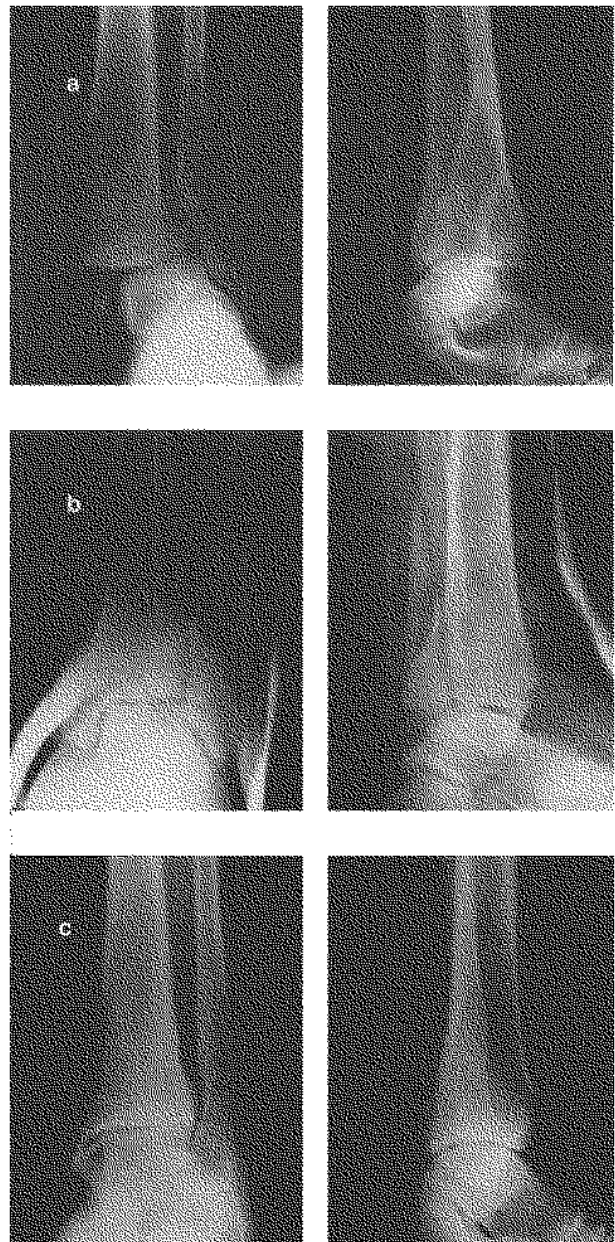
Radiographs showing closed treatment of a tri-malleolar fracture (PE stage IV) with severe talar shift.
